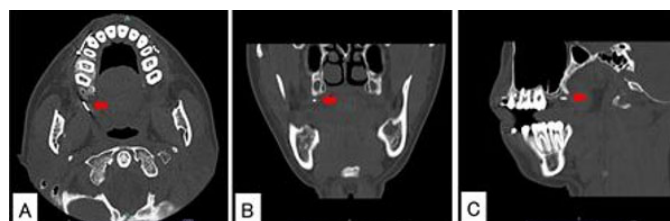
(A) Axial, (B) coronal, and (C) sagittal computed tomography images showed a linear high-density area approximately 7 mm in length, which was located 13 mm posterior to the distolingual cusp of the right maxillary second molar and 8 mm superior to the occlusal plane of the maxilla (red arrows).
